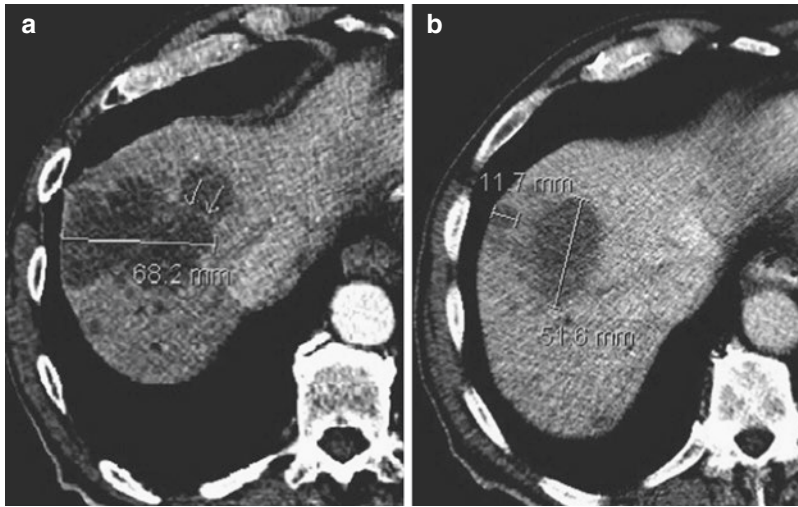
Splitting lesions. On a CT image, (a) a metastatic “target” lesion in the liver is shown, with a maximum diameter of 68.2 mm, which is separated from another adjacent lesion by a thin line of normal-appearing liver parenchyma (arrows). On follow-up CT (b), after
